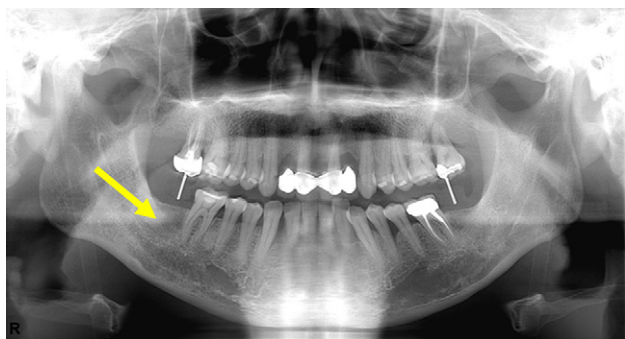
The arrow indicates an image with bone-like density within the tooth 47 extraction socket before implant placement on panoramic radiography.
